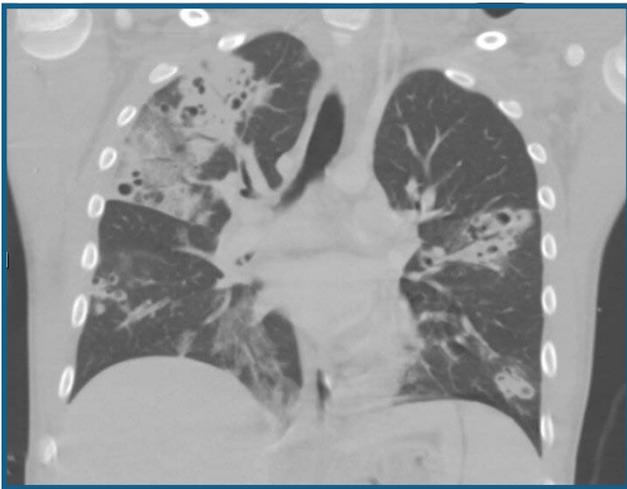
Computerized tomography (CT) scans of the chest demonstrating multifocal areas of dense opacification surrounding large cystic spaces throughout the lung lobes. Some of these may be filled with debris or mucous.
